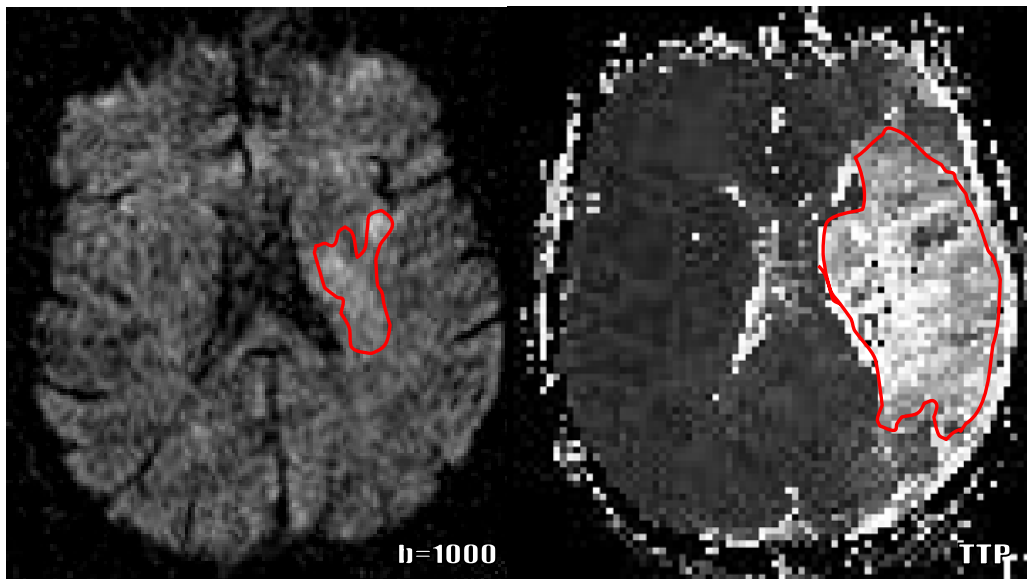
DWI and PWI images. The ROIs were drawn contouring the hyperintensive abnormalities on the images. The volume equals to area x (slice thickness+gap). The diffusion/perfusion volume ratio is $<1/3$ in this patient.
